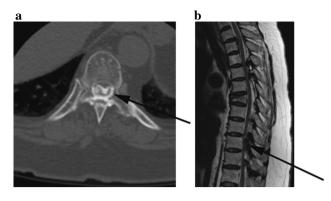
Axial CT scan (a) and sagittal MRI (b) showing an example of OYL with dural ossification. Note the 'comma sign' as showed by the *arrow*. Intra-operatively, there was severe dural ossification with the dura merging with the OYL. Patch repair with fascia and fat was performed after decompression
